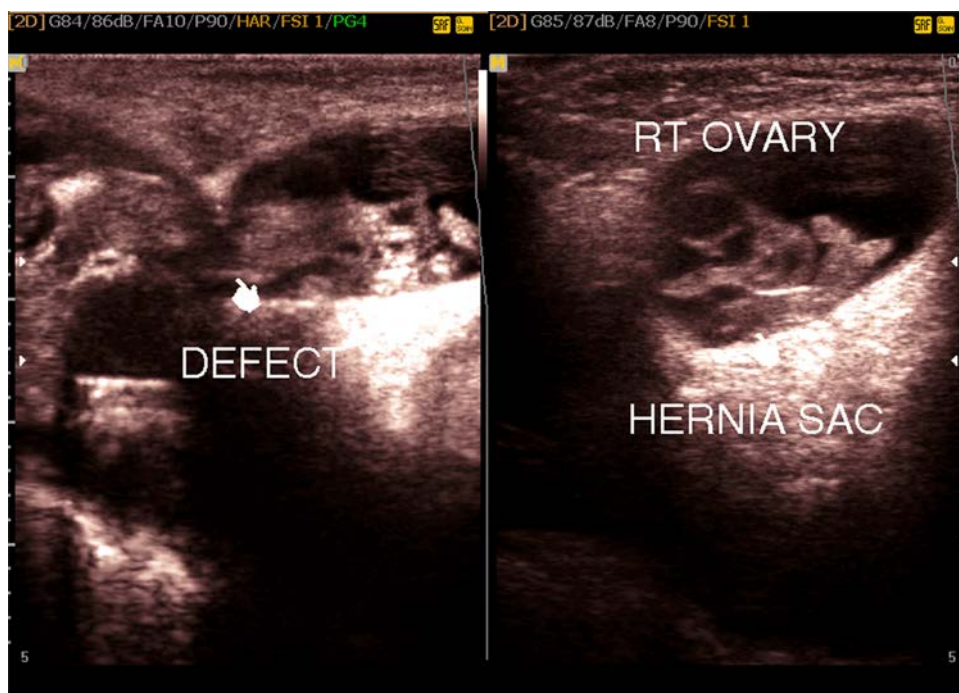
Ultrasound exam revealed female inguinal hernia with an ovary, tube and fluid inside the hernia sac.
